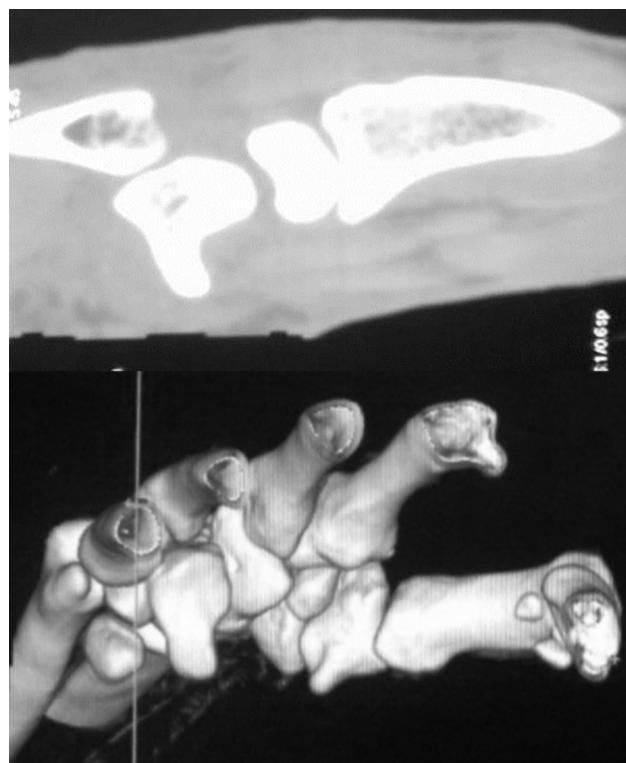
CT scan through fourth metacarpal shows dislocated fourth CMC joint and empty hamate. 3D CT showing dorsally dislocated fourth and fifth metacarpals with empty hamate and slight subluxation of third CMC joint.
